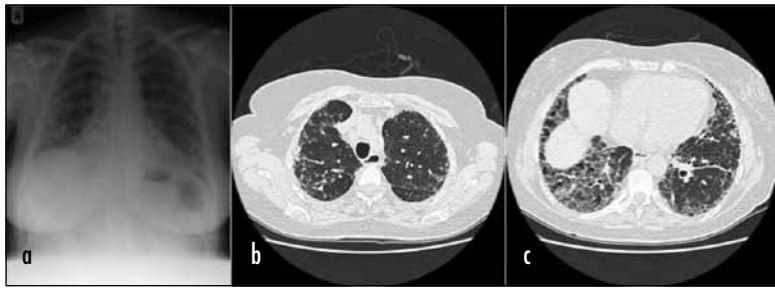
Images from a patient with systemic sclerosis-related pulmonary fibrosis. *a.* Chest radiograph demonstrating bibasilar opacification consistent with pulmonary fibrosis. *b.* High resolution computed tomography image through the upper zones demonstrating peripheral predominantly interstitial shadowing. *c.* High resolution computed tomography chest image through the lung bases showing both interstitial and airspace shadowing, the appearances are in keeping with non-specific interstitial pneumonia. There is also significant traction bronchiectasis.
